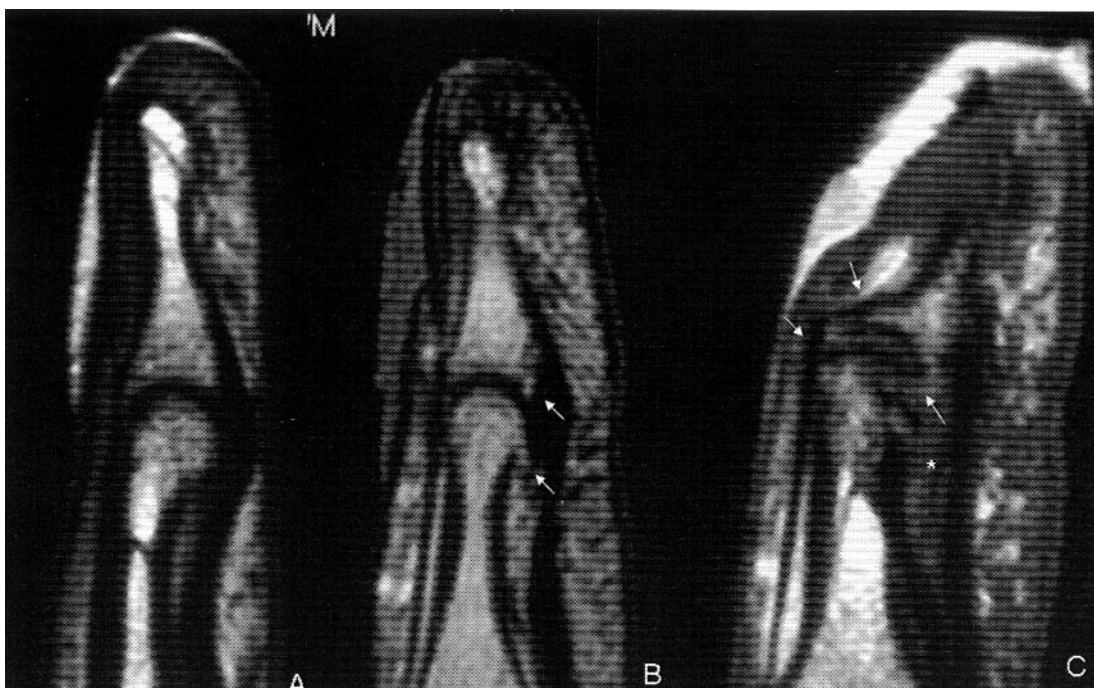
MRI of the distal phalanx: TSE T1 sagittal (A and C) and TSE T2 sagittal (B) images. A. Normal DIP joint structure in a control subject. B and C. In a patient with PsA with no onychopathy (B) marginal syndesmophytosis (arrows) can be detected; in a PsA patient with onychopathy (C) there is advanced morphological abnormality of the DIP joint (arrows), with anterior partial luxation and capping. A reaction of the nearer soft tissue is also evident (asterisk), with enthesopathy of the flexor tendon.
